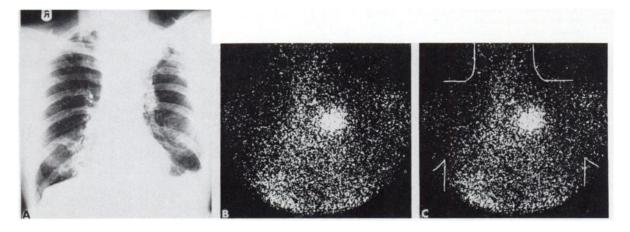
Patient with old tuberculous scar in left upper lobe of lung. (A) Chest x-ray; (B) anterior scintigram of thorax shows radioactivity in lesion (first indication of malignancy in addition to
